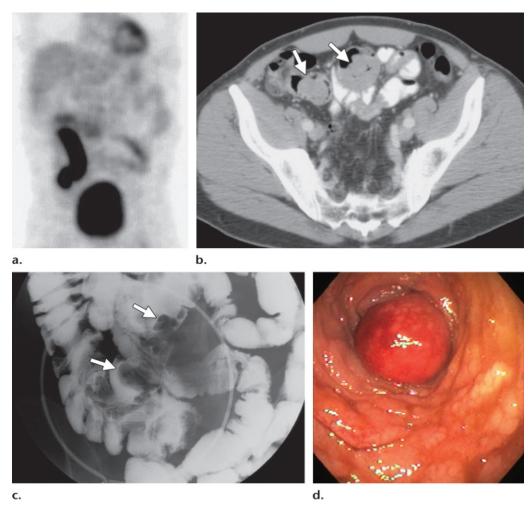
Recurrent mantle cell lymphoma in a 55-year-old man during routine surveillance. (a) FDG PET image shows curvilinear uptake in the right lower quadrant. (b) Axial CT image with intravenous and oral contrast material shows multiple intraluminal polypoid masses in the distal ileum (arrows). (c) Spot image from small-bowel follow-through study shows several polypoid masses in the terminal ileum (arrows). (d) Photograph from optical colonoscopy confirms the presence of a polypoid lesion in the distal ileum.
